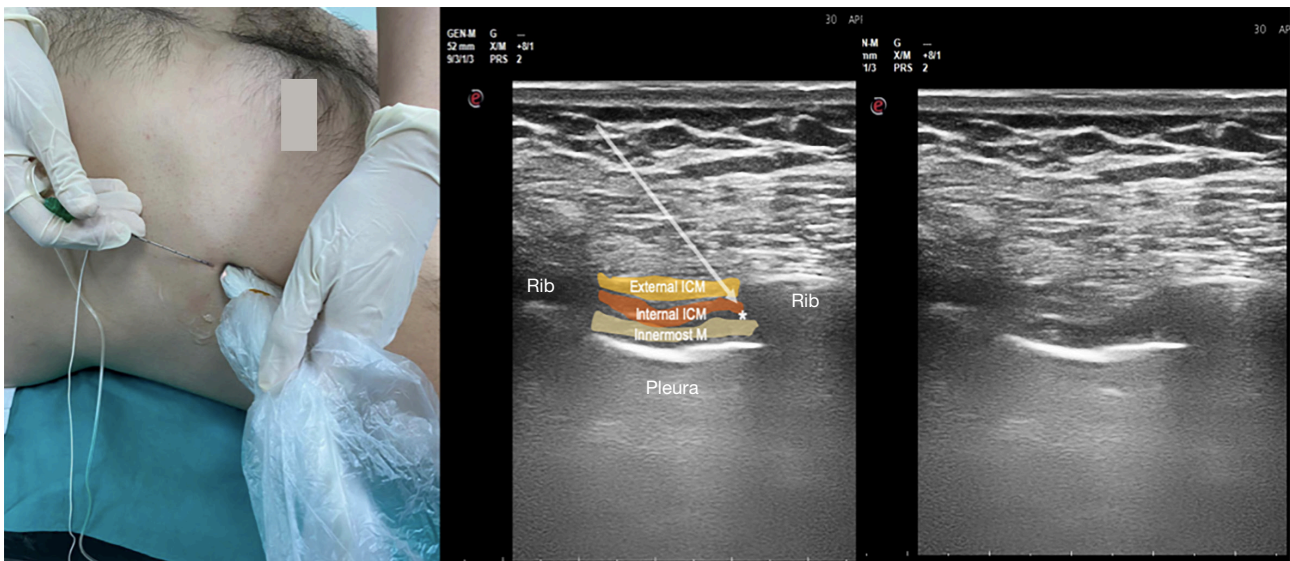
Ultrasound probe positioning and sonographic image of the intercostal nerve block. This image is published with the patient/participant's consent. *, needle tip place. ICM, intercostal muscle.
